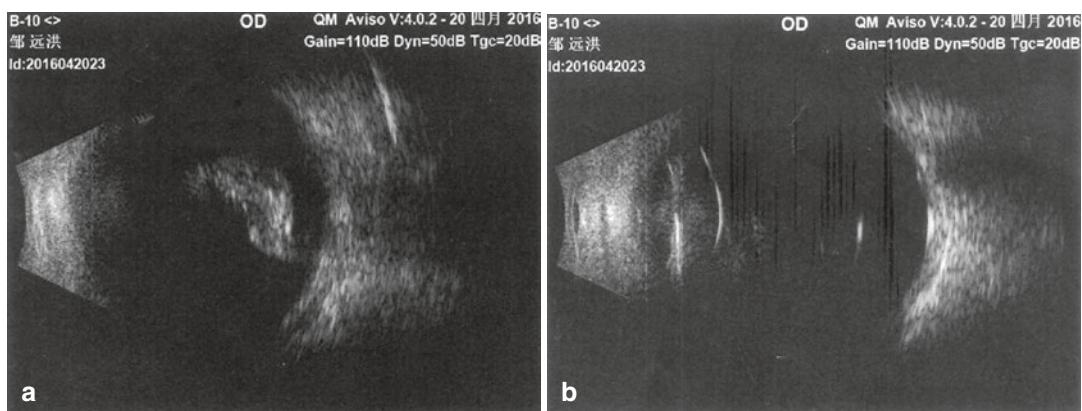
B-scan ultrasonography of the injured eye. (a) The vitreous hemorrhage was manifested as moving internal echoes in posterior segment. (b) The possible foreign body located at the posterior eyewall
